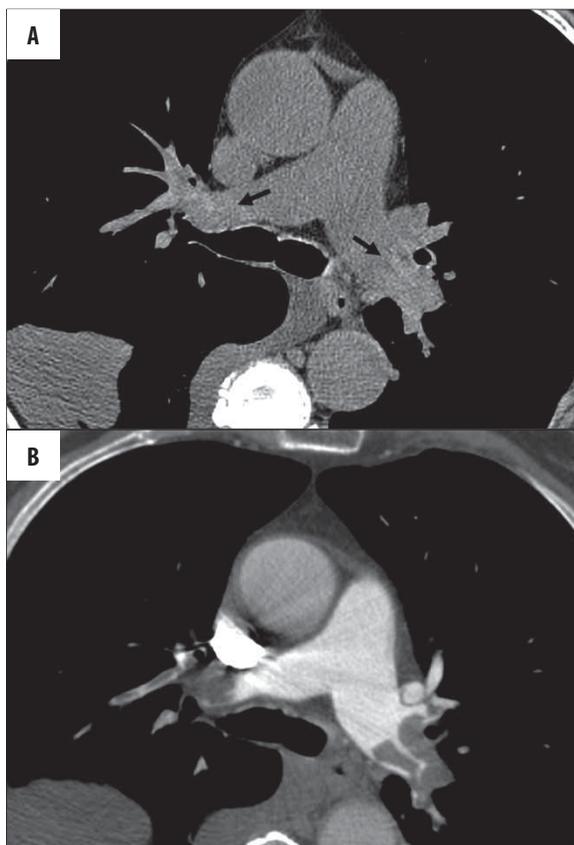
Hyperattenuating material located in right and left pulmonary arteries at unenhanced CT (A). CTA demonstrates acute pulmonary embolism (B).
